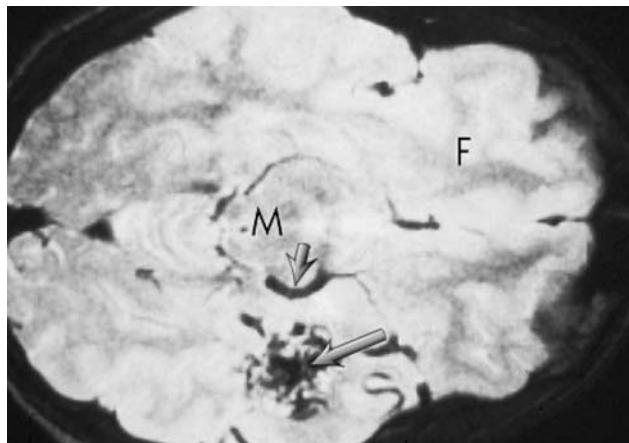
An arteriovenous malformation (large arrow) is visible in an MRI scan taken in the horizontal plane. The lesion is in the left temporal lobe. Note the large size of the posterior cerebral artery (small arrow) ipsilateral to the lesion. F, frontal lobe; M, midbrain.
